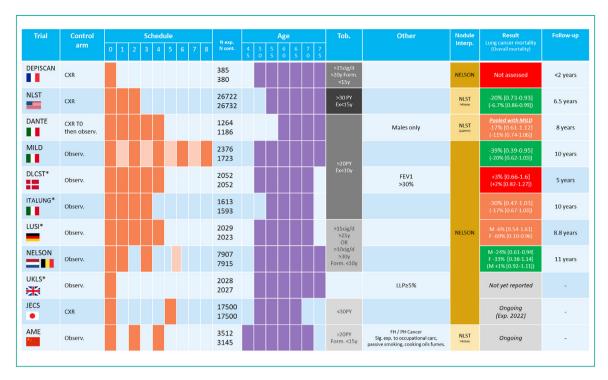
Randomized trials on low-dose computed tomography for lung cancer screening.
